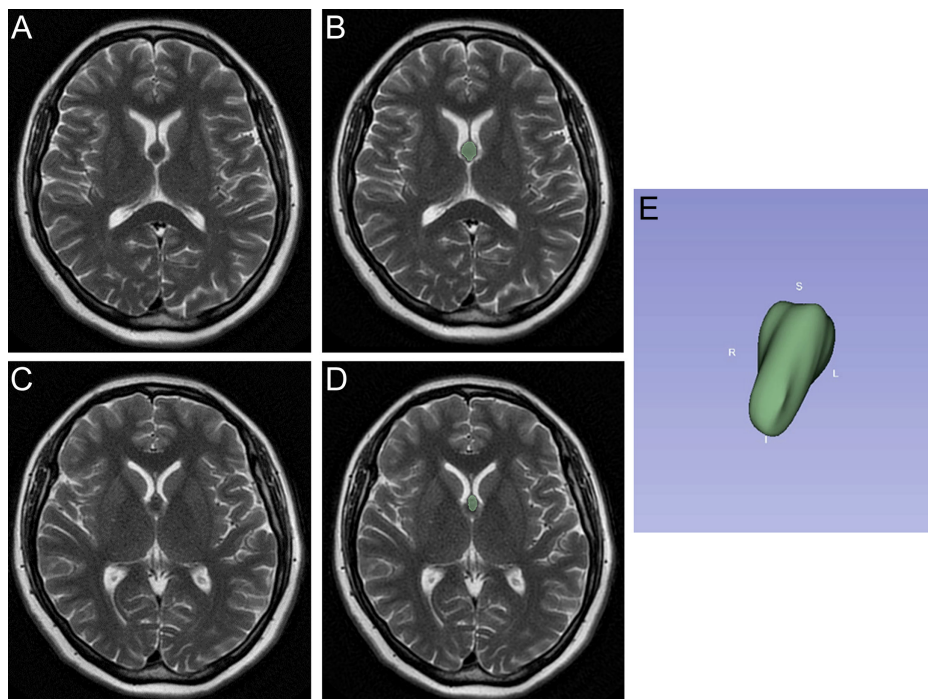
Magnetic resonance imaging in a 46-year-old female presenting with headache. (A and C) Axial T2-weighted spin-echo images show a rounded, hypointense mass in the anterior aspect of the third ventricle. (B and D) The segmentation of colloid cysts at the same level is shown. (E) 3D volume rendering AP projection obtained by segmentation from T2-weighted sequences shows the colloid cyst. (AP, anteroposterior)
